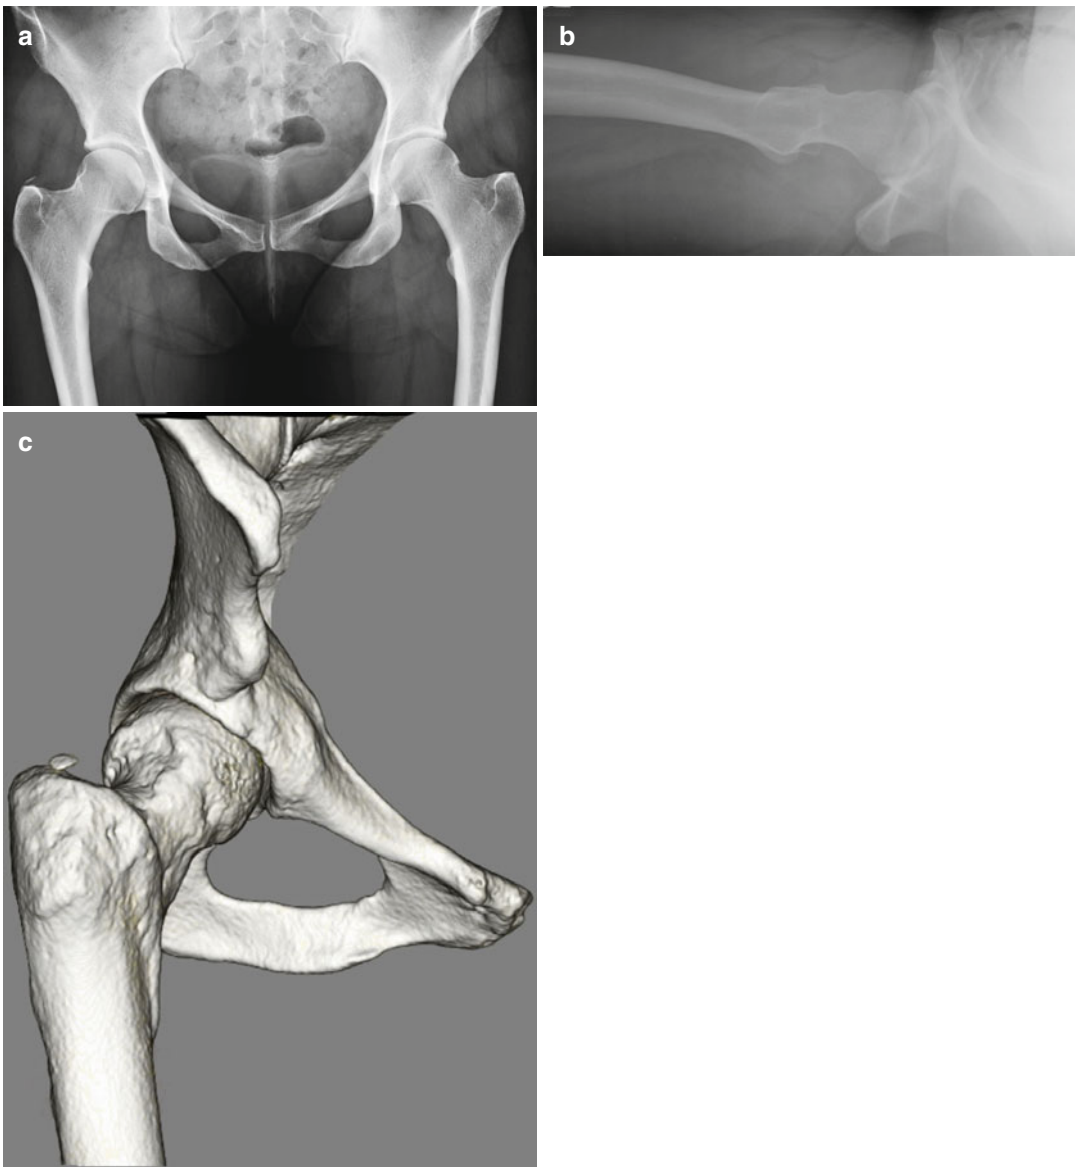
AP (a), cross-table lateral (b), and 3D CT image (c) of a 32-year-old woman who had persistent symptoms of FAI 1 year following incomplete resection;
